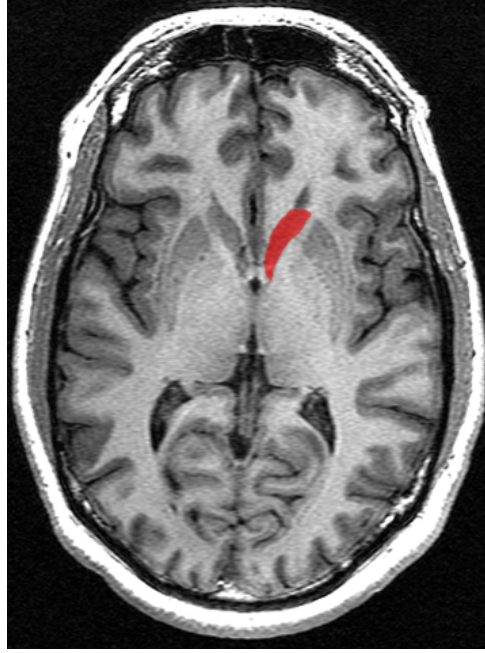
Transverse view of the caudate nucleus (highlighted in red) in a structural MRI. Image credited to Geoffrey Hall, McMaster University, Canada.
